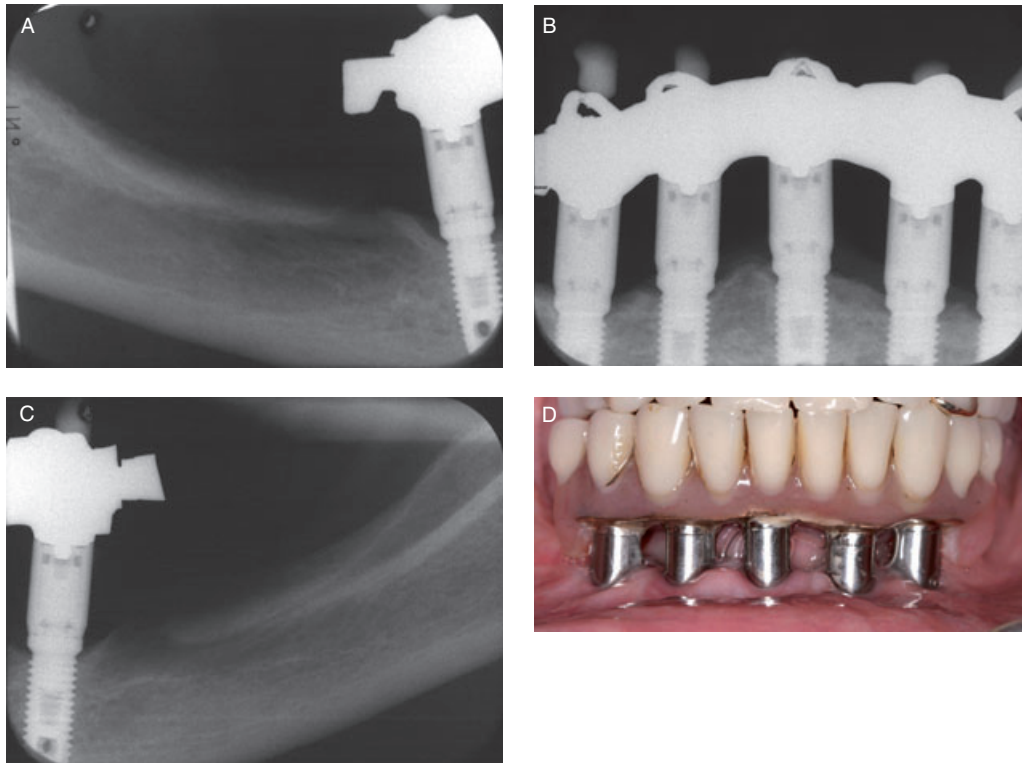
Sixty-five-year-old woman, who at the age of 45 was treated with five mandibular implants. Radiographs demonstrating good bony support of the implants (A–C) and the clinical situation (D) 20 years after treatment.
